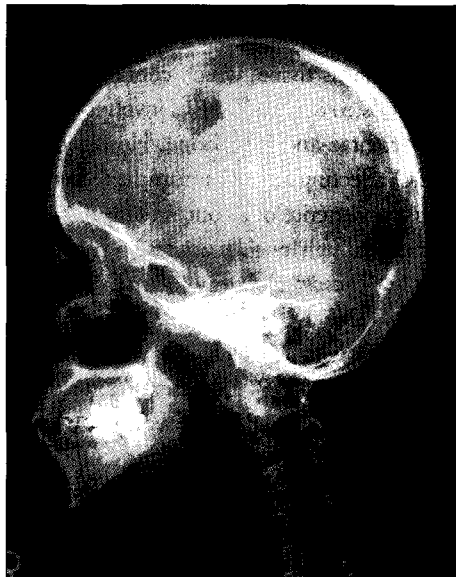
Plain roentgenogram of the skull, lateral view, showing a lobulated osteolytic lesion on the right frontoparietal skull.
